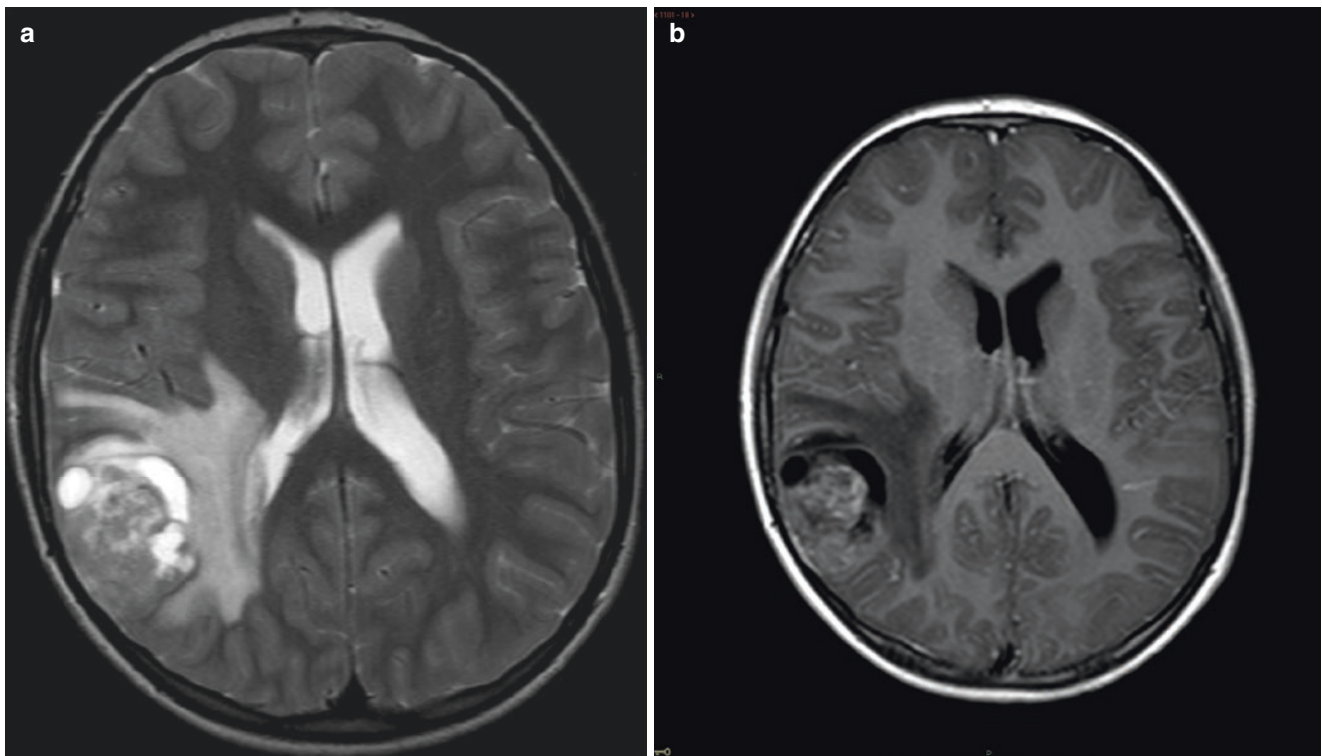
Right parietal pleomorphic astrocytoma. (a) Axial T2-weighted MR image demonstrates a heterogeneous lesion in the right parietal lobe, containing solid and cystic areas. There is significant
